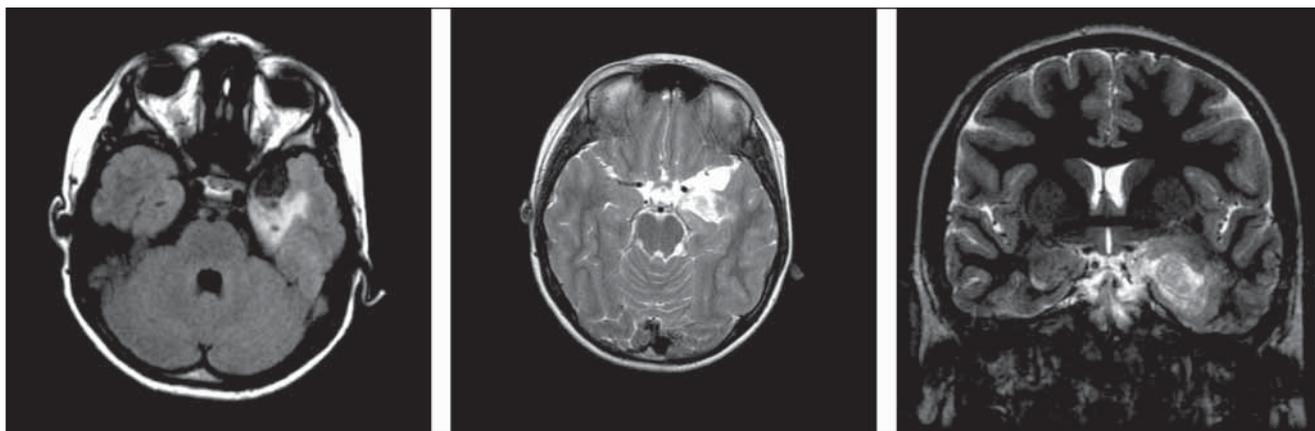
MRI without enhancement
